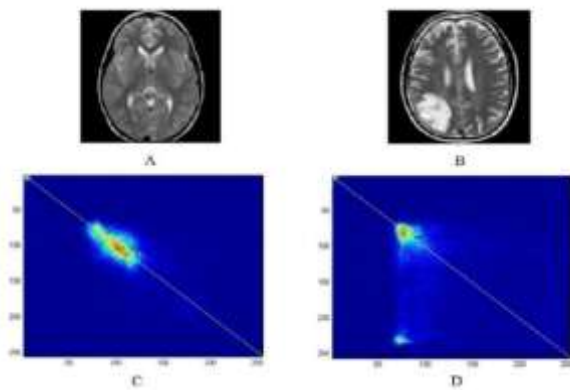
A) MRI normal brain slice, B) MRI abnormal brain slice, C) MGLCM of normal brain scanning and D) MGLCM of abnormal brain scanning
